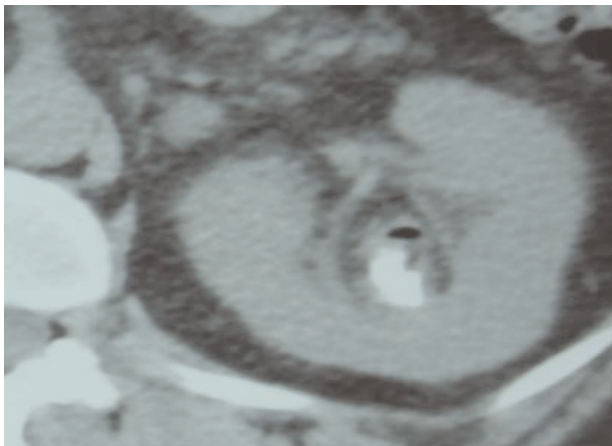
Abdominal computed tomography without contrast material administration: Emphysematous pyelitis of the left kidney with a renal pelvic calculus and gas within the renal pelvis.
